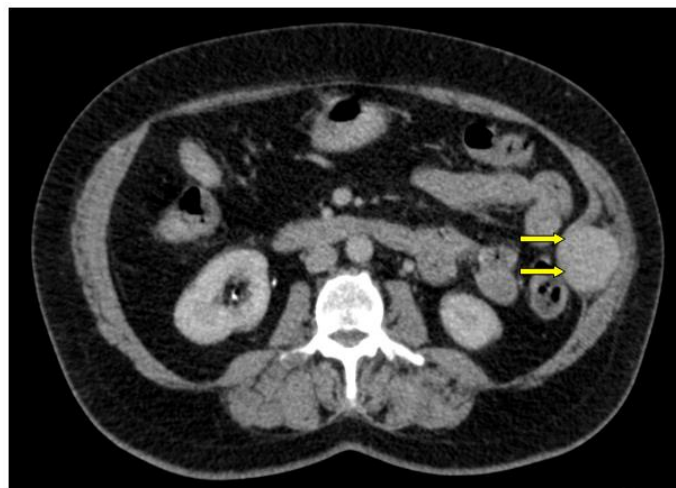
Abdominal CT scan with PDC injection; arterial phase (axial slice) which has objectified: heterogeneous enhancement of the mass (arrow)
